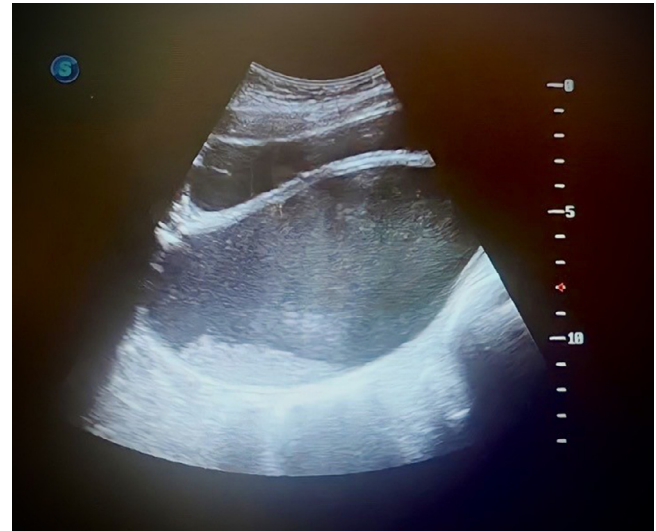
An ultrasonic view of hematocolpos. Transabdominal ultrasonographic view showing the markedly distended vagina measuring 13 × 8 cm.
